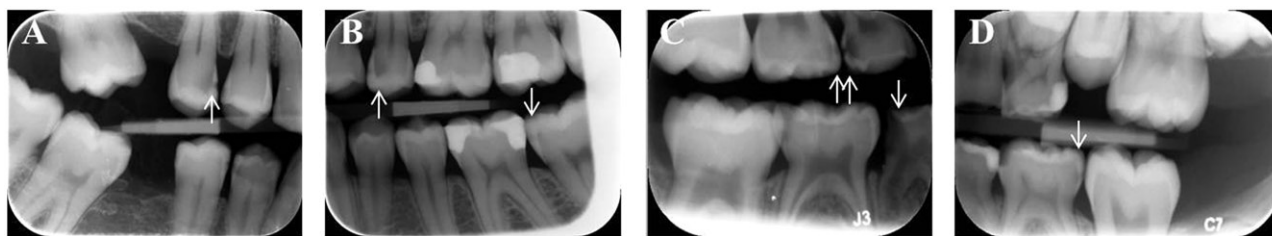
Radiographic classification of the caries lesions in permanent and primary teeth.
